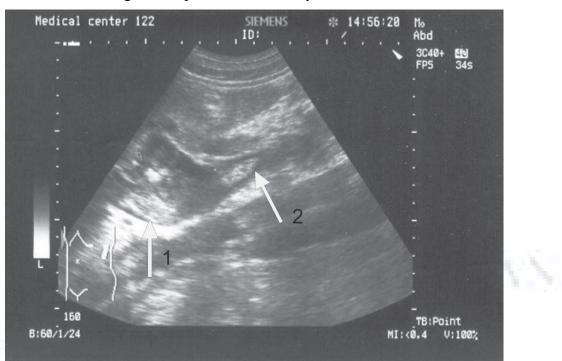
Sonogram of the left kidney (Simens Sienna, 3.5 MHz).
